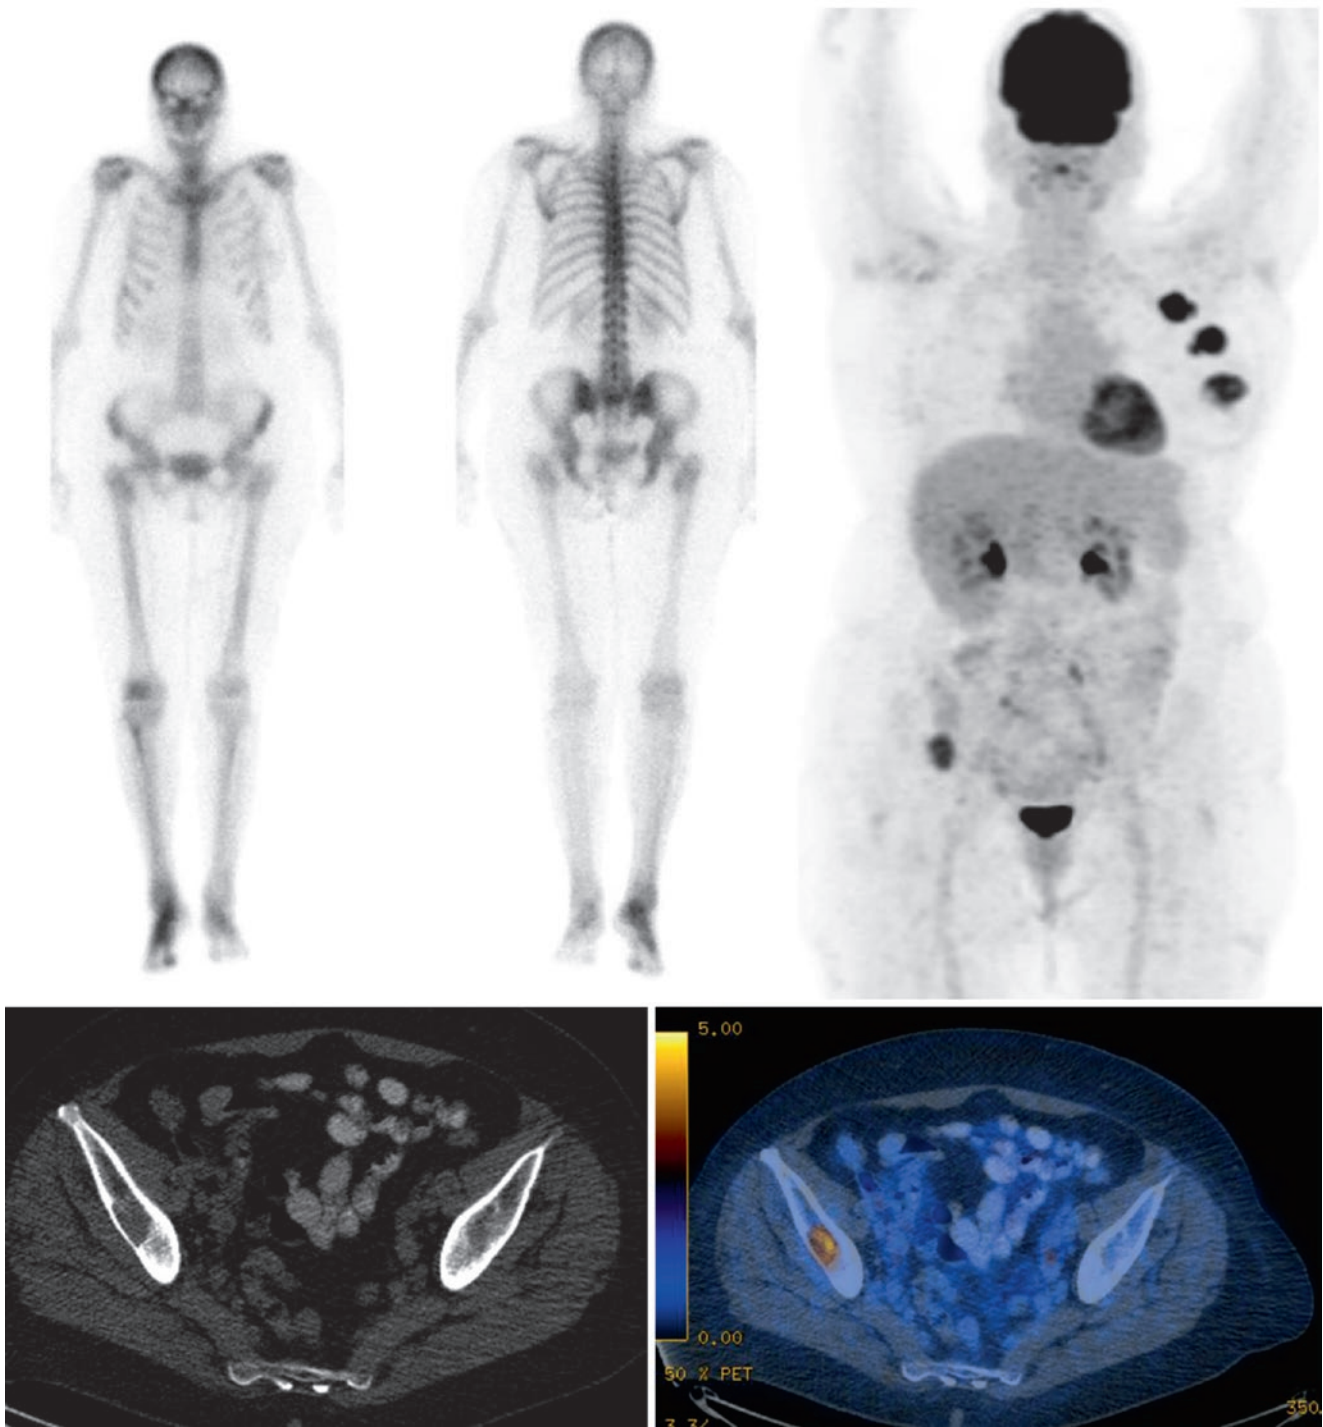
Patient with breast cancer and normal bone scan. FDG PET/CT shows pathologic FDG uptake in an osteolytic bone metastasis in the right iliac bone and multiple active lymph node metastases in the left axilla
